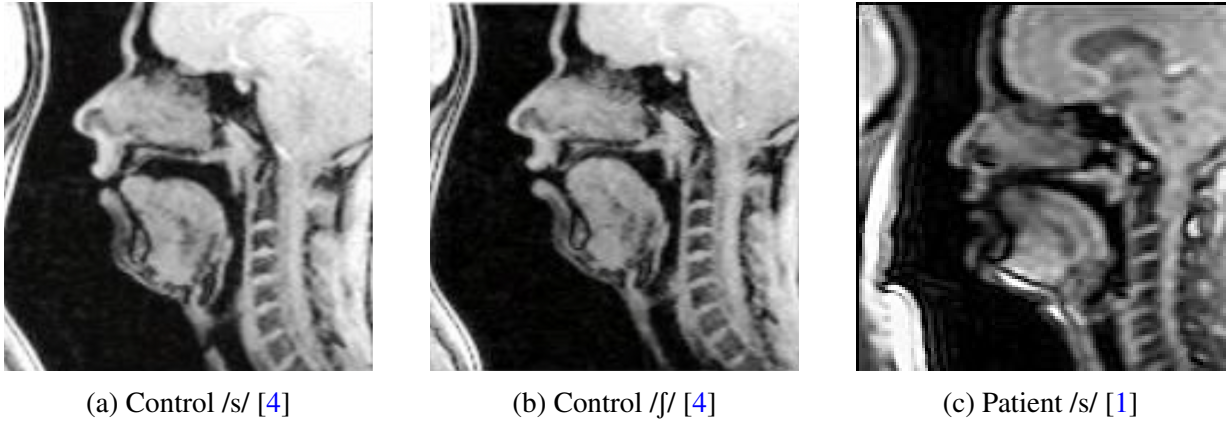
Midsagittal MRI of sibilant fricatives
